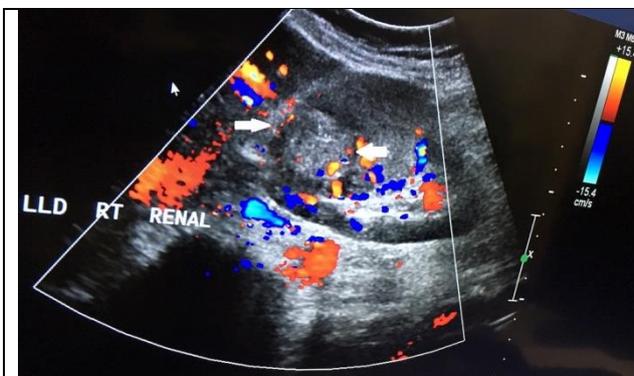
Fig a. Ultrasound of the right kidney shows increased vascularity, and a mass (white arrows) with areas of necrosis.
